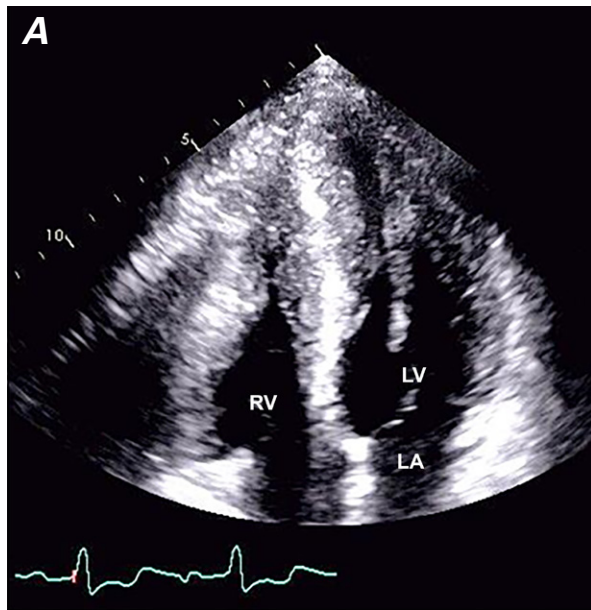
Transthoracic echocardiograms (apical 4-chamber views) show A) myocardial hypertrophy of the ventricular septum, the anterior wall of the left ventricle, and the apex of both ventricles at end-diastole, and B) midventricular obstruction with an apical chamber at end-systole (arrow). C) Color-Doppler M-mode image shows the near-absence of midventricular flow during late systole and the diastolic paradoxical jet flow from the apex toward the base of the left ventricle (arrow). D) Continuous-wave Doppler-mode image shows bimodal flows toward the base of the left ventricle with a notch between end-systole and early-diastole (arrowhead). E) Color-Doppler M-mode image and a phonocardiogram obtained at the apex show the first part of a diastolic murmur after S_2 (white asterisk) coinciding with the diastolic paradoxical jet flow (arrow) and the last part of the murmur (arrowhead) coinciding with the mitral E wave (black asterisk). The phonocardiogram is not identical to that shown in Figure 1 because it was recorded by using a simple phonocardiograph connected to the echocardiograph. The probe used to obtain the corresponding echocardiogram was not placed at the true apex because a microphone for phonocardiography was placed in that location.
